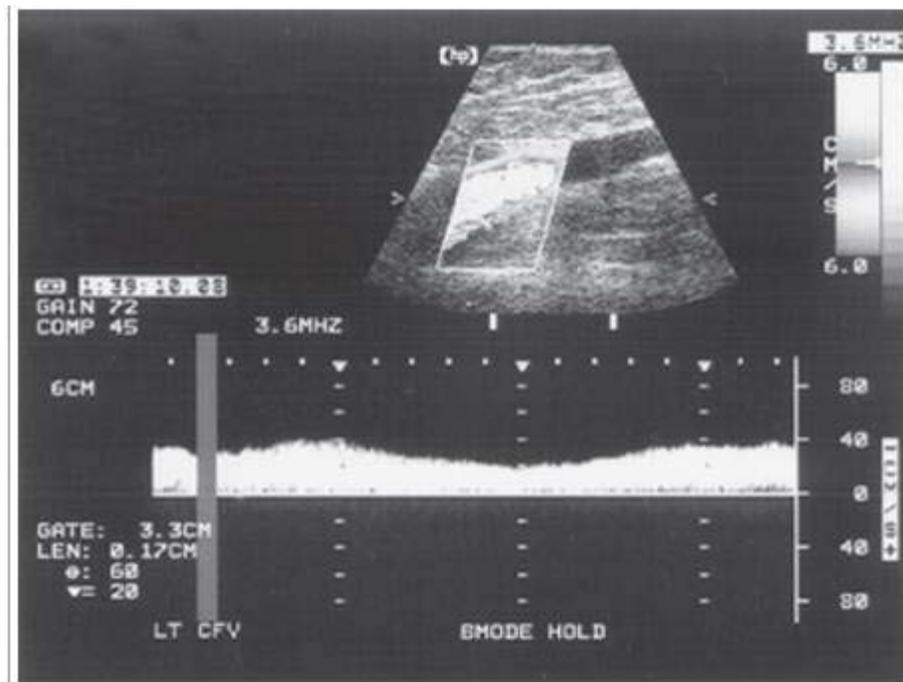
Duplex ultrasound scan of a normal femoral vein with phasic flow signals.
